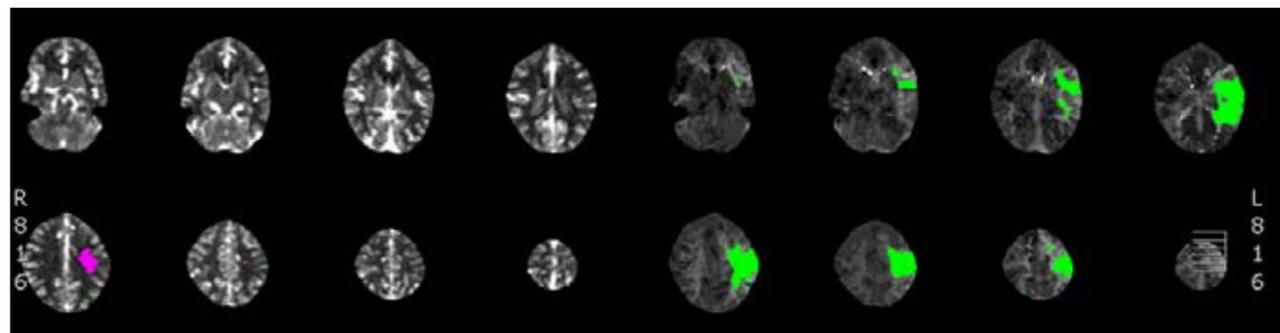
CT perfusion scan showing mismatch
